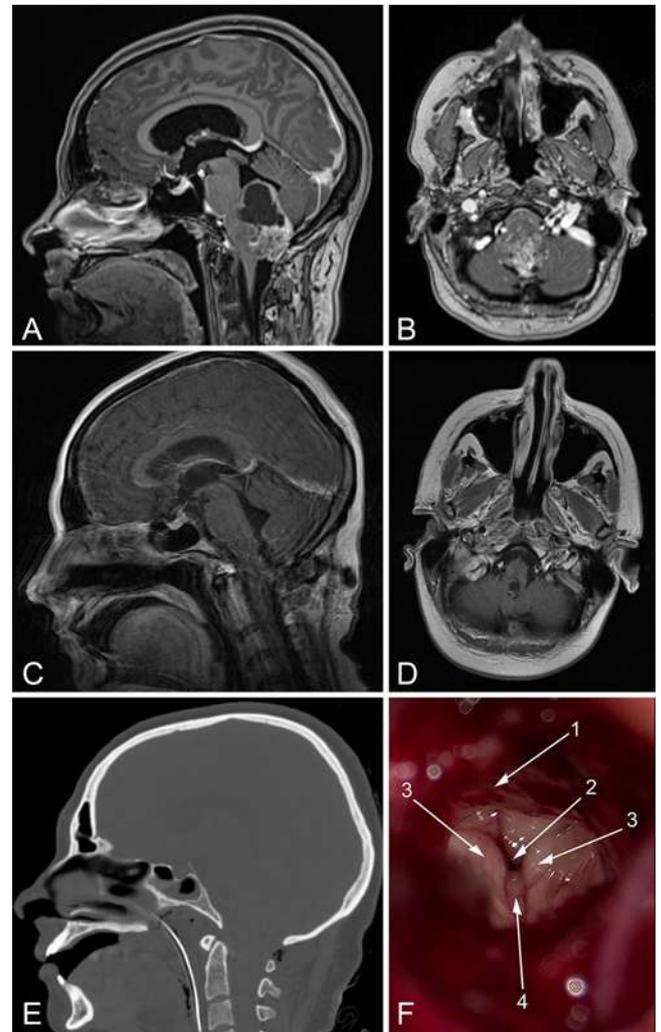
Case 2. Resection of anaplastic ependymoma of the fourth ventricle through the AOM. A and B: Preoperative contrast-enhanced sagittal T1-weighted (A) and axial (B) MR images showing a large tumor of the fourth ventricle with extensive invasion into the brainstem. C and D: Contrast-enhanced sagittal T1-weighted (C) and axial (D) MR images obtained on day 12 after surgery, showing no tumor remnants. E: Sagittal CT reconstruction after surgery. F: Intraoperative photograph after gross-total tumor resection (F). 1, tumor-infiltrated rhomboid fossa; 2, caudal part of the cerebral aqueduct; 3, superior cerebellar peduncles; 4, superior velum medullare. Figure is available in color online only.
